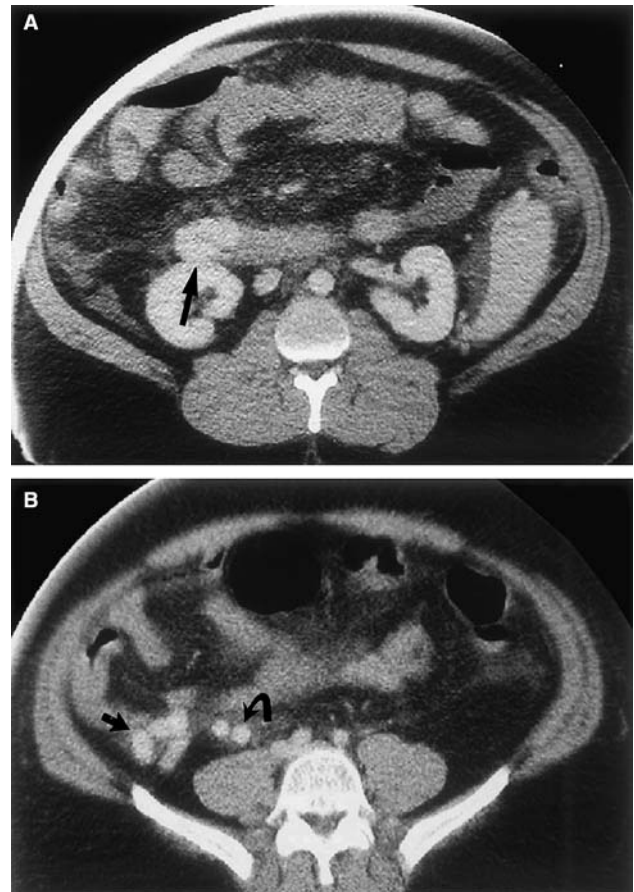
Case 3. A Axial CT scan with intravenous contrast demonstrates large duodenal varices (arrow). B Axial CT scan with intravenous contrast demonstrates the mesenteric varices (arrow) draining into the right gonadal vein (curve arrow).
